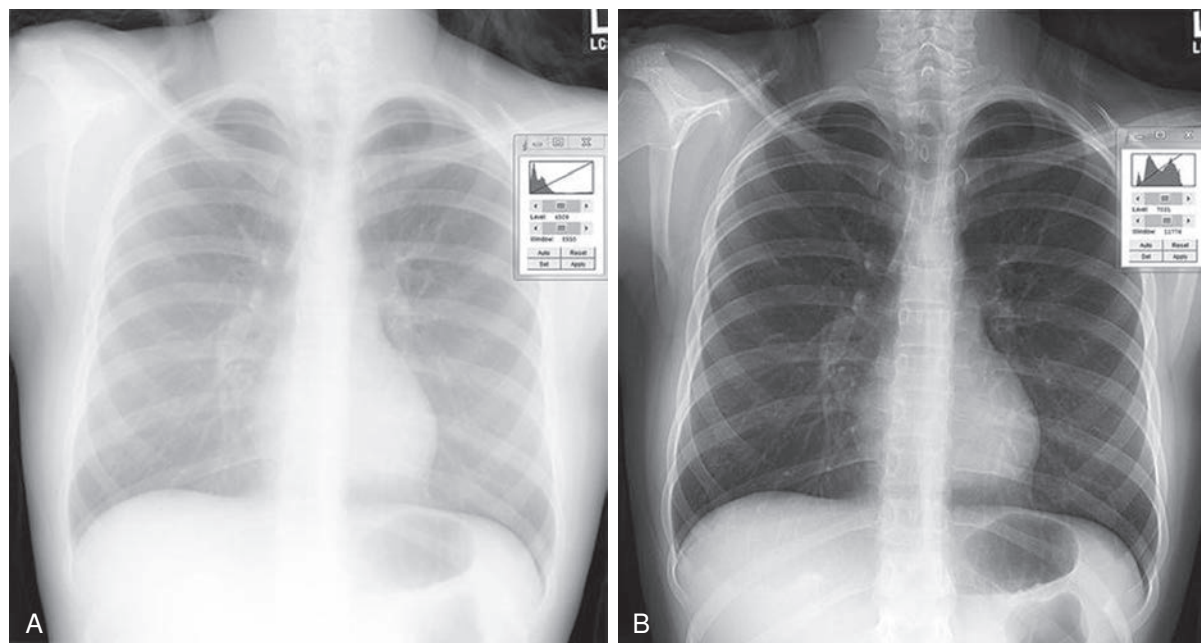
Digital Image Contrast and Brightness. Contrast and brightness scales of raw image data can easily be manipulated with computed radiography/digital radiography postprocessing tools. (A) shows a long scale of contrast, whereas (B) appears darker with a short contrast scale.
